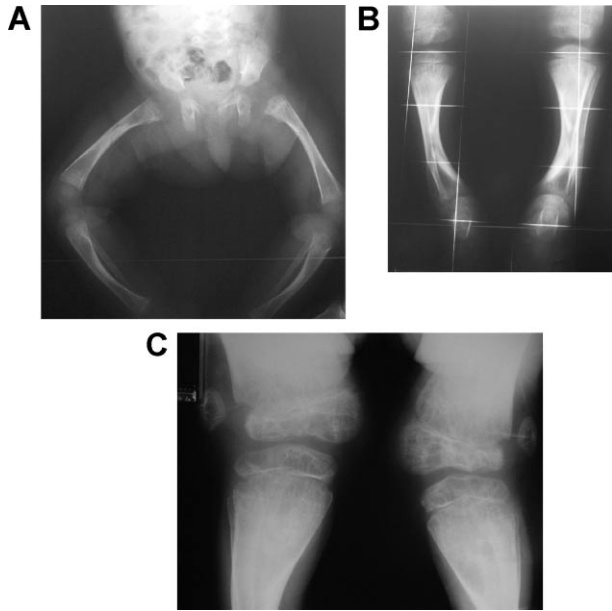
Radiograph of lower limbs at 2 months (A), 3 years (B), and 11 years (C). Note the progressive bowing of long bones, internal cortical thickening at the concave site, involvement of fibula from 6 years on, enlarged distal metaphyses, and irregular trabeculation. At 11 years there are cystic changes in tibia and fibula, osteopenia, and fragmentation of epiphyses.
